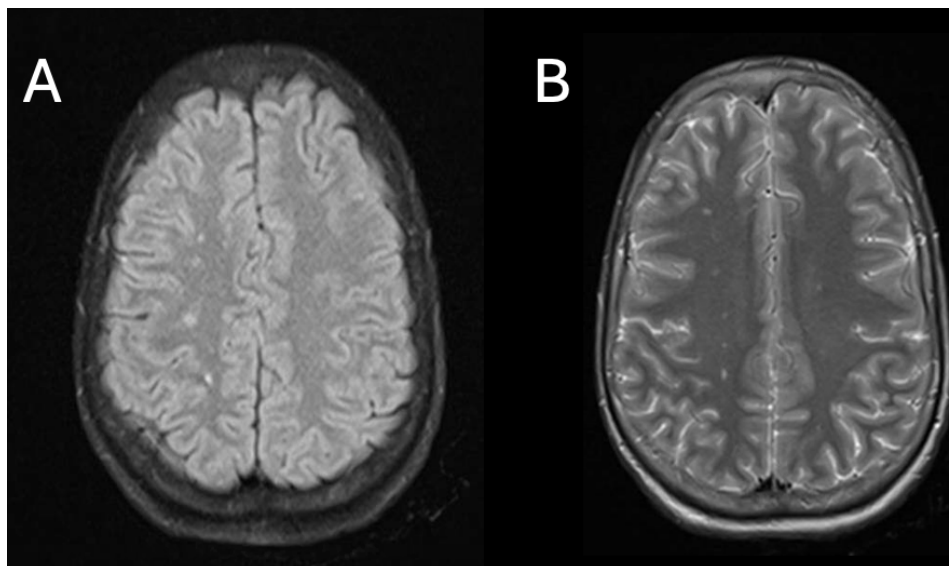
(A) FLAIR imaging reveals abnormal hyperintensity in the bilateral white matter, indicating areas of potential tissue injury or edema. (B) T2-weighted imaging further emphasizes these regions, highlighting the same areas of hyperintensity in the bilateral white matter.
